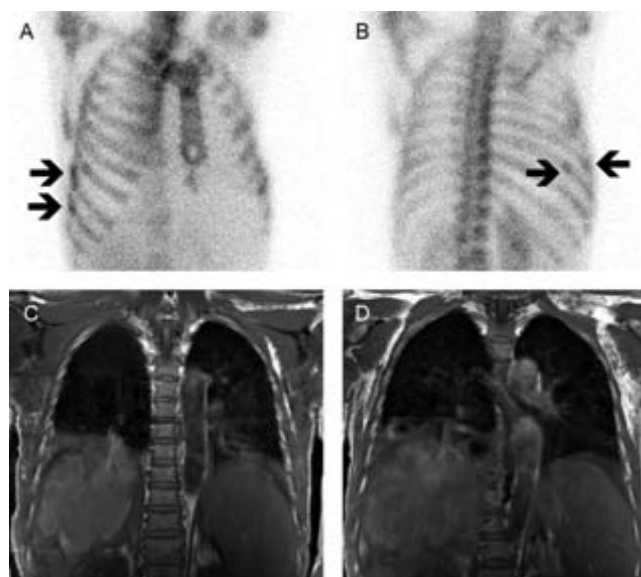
(A, B) Bone scintigraphy shows probably positive lesions at lateral right 7 – 8 ribs (arrow) but no lesion can be detected on coronal T1 weighted image (C,D).
